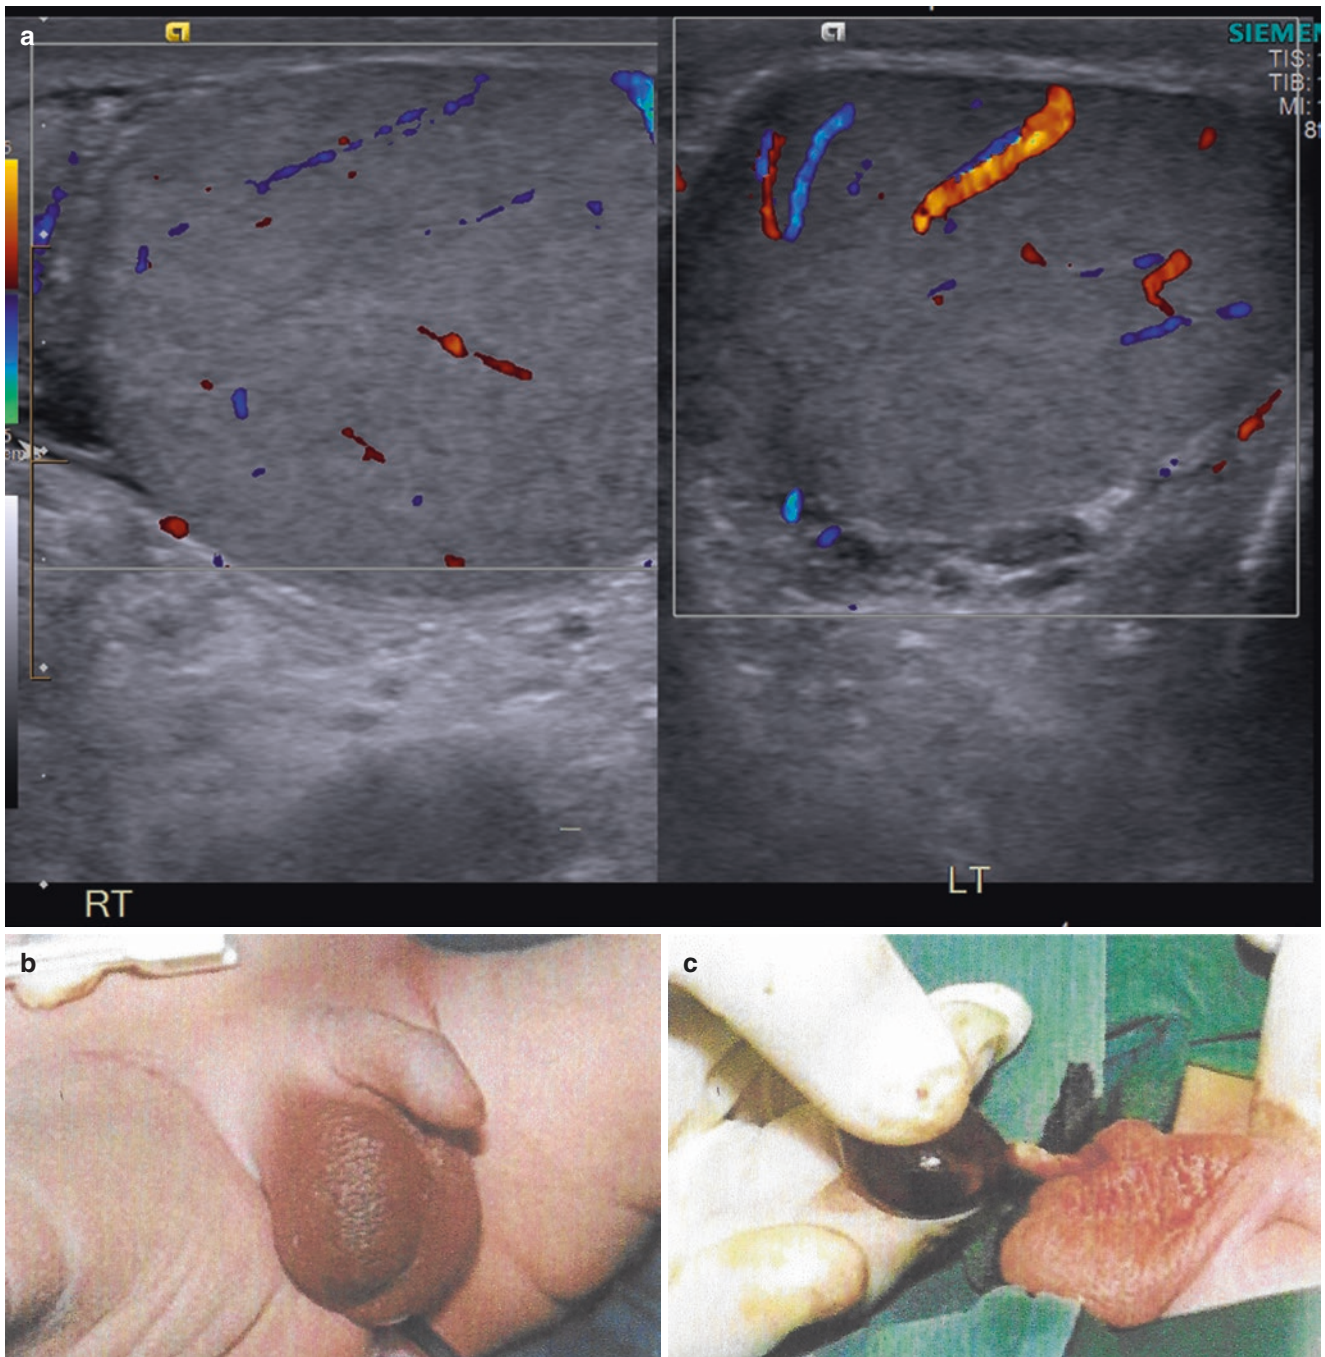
(a) Axial ultrasound image of the testes. The symptomatic right testis shows reduced Doppler flow relative the left. Torsion was confirmed at surgery. (b) Clinical picture of acute torsion of the testis in a neonate. (c) Intra operative findings of torsion of the testis
